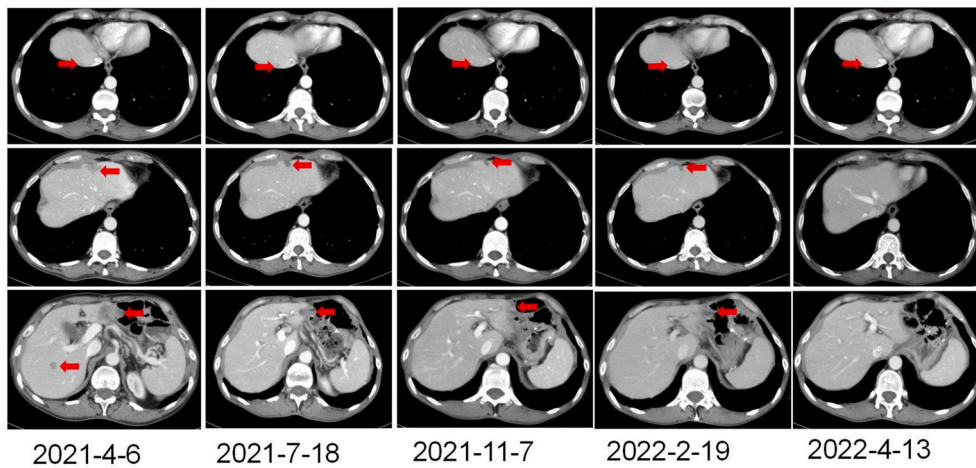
Changes in CT images.
